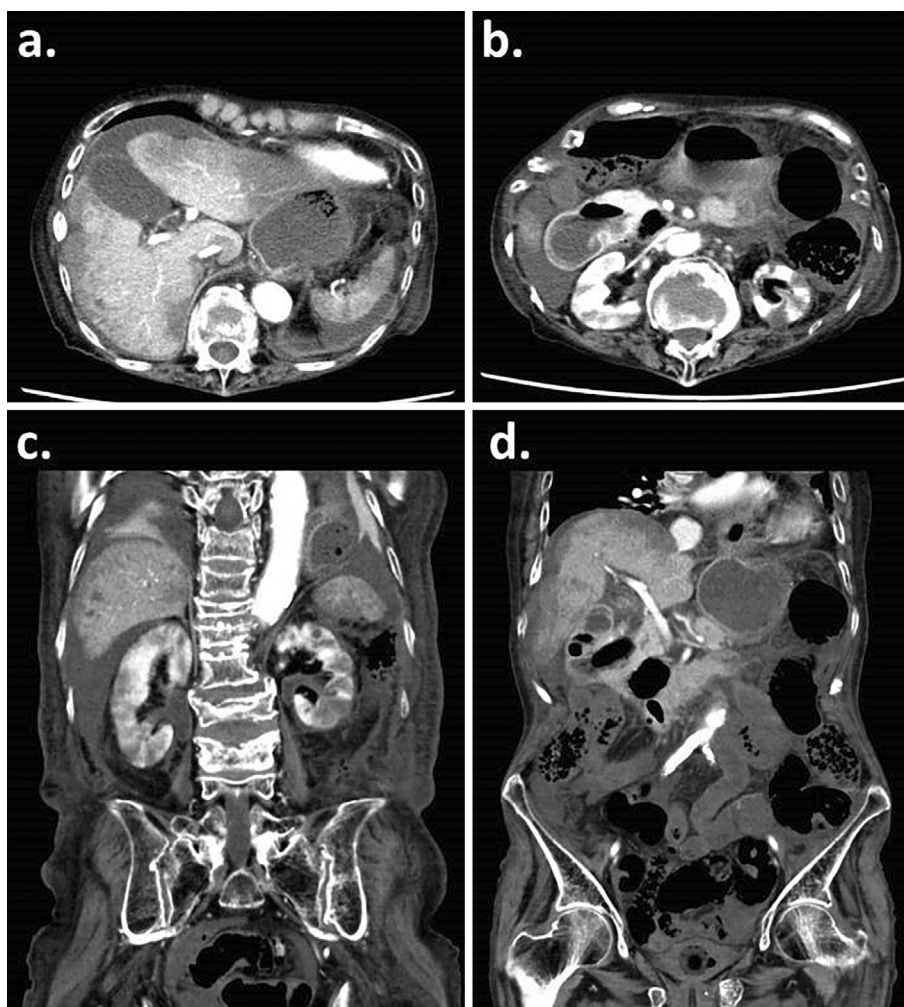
Imaging findings of acute multiple thrombosis. a, b The transverse section and c, d the coronal section of abdominal enhanced computed tomography on the 48th hospital day. The development of multiple infarctions of the kidney, liver, and spleen are demonstrated. The stomach, small intestine except for duodenum, and colon are not enhanced because of an impaired arterial blood flow.
